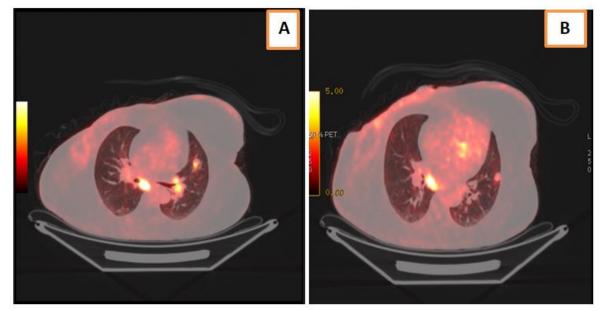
A) PET-CT axial section showing a pathological hypermetabolic pulmonary nodule of the left lung (lingula), and left pulmonary hilar and subcarinal lymph node hypermetabolism; B) PET-CT axial section showing a pathological hypermetabolic subpleural lung nodule (in the left lower lobe)
